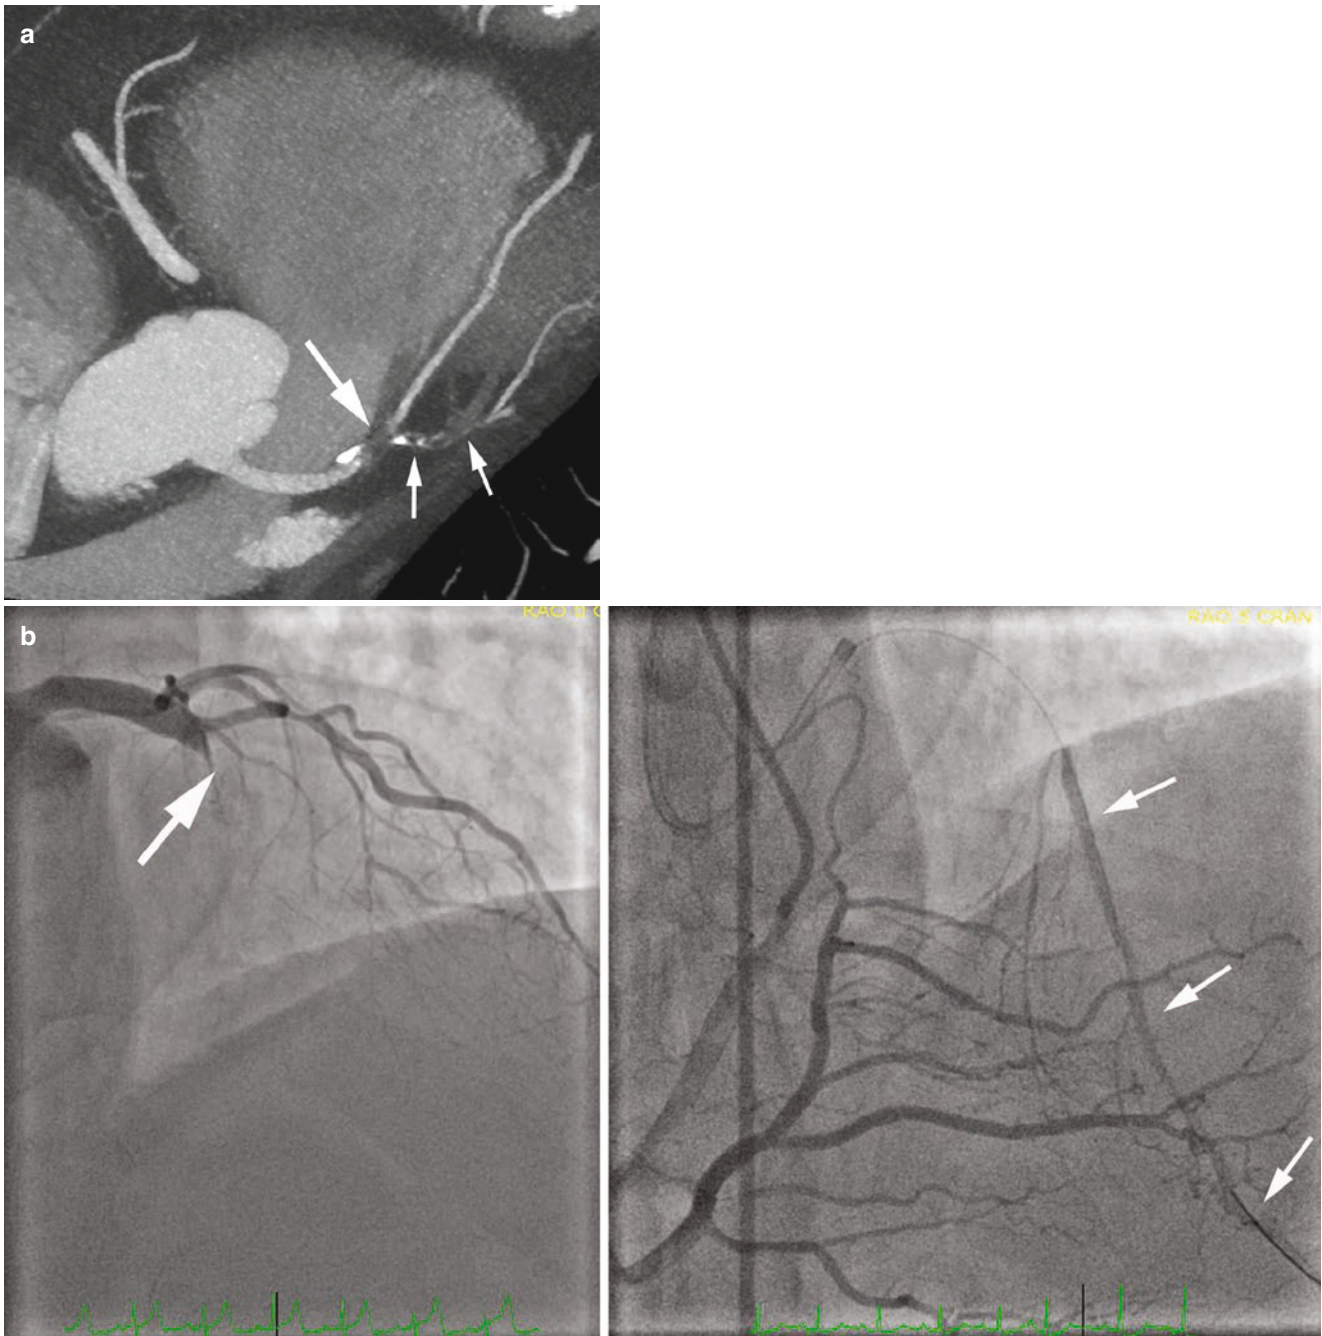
Chronic total occlusion of the mid left anterior descending coronary artery. (a) Maximum intensity projection. (b) Curved multiplanar reconstruction in coronary CT angiography. The occluded segment with complete interruption of the contrast-enhanced lumen (*large arrows*) and contrast enhancement of the distal coronary artery via collaterals (*small arrows*) is visualized. The occlusion is noncalcified, not
